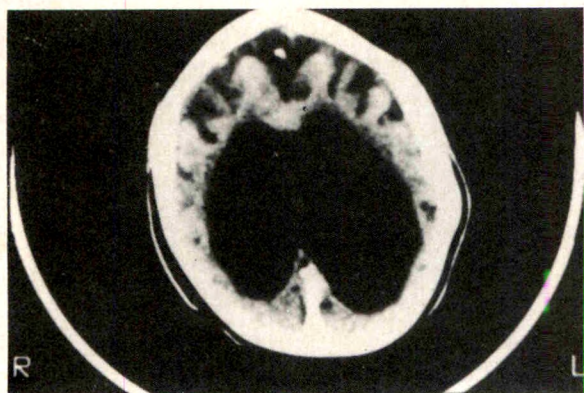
(Desai and associates). Computed tomographic scan of the brain showing semilobar holoprosencephaly.
